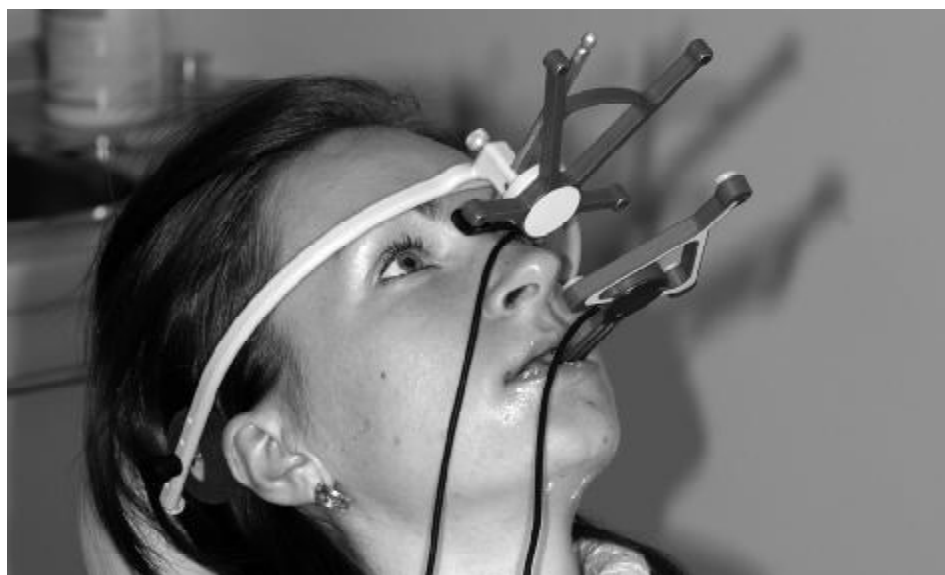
Ultrasonic device ARCUSdigma adjusted to head of patient
